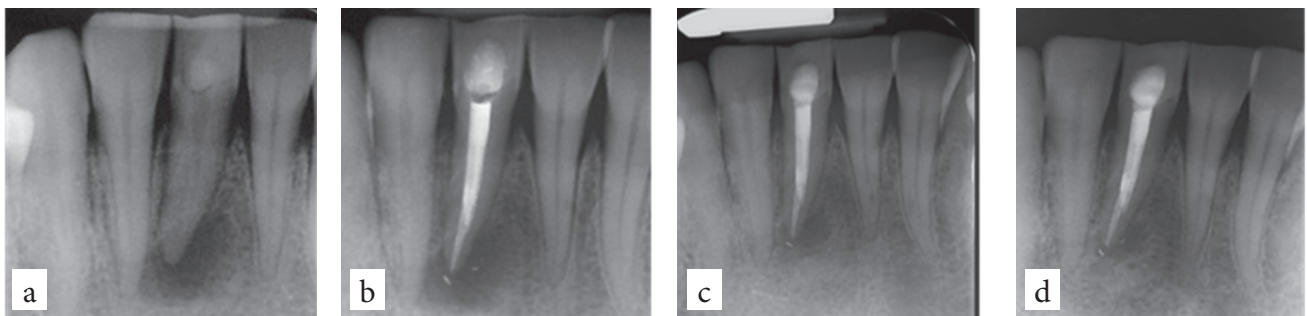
Example of mandibular incisor with well defined radio-transparent periodontitis (PAI 4). After root canal treatment and filling with a very small overfilling, the lesion decreased to PAI 3, the clinical symptoms disappeared, the tooth is functional, but lesion persists at 1 and even 3 years follow-ups as well as overfilling, suggesting an extended period of time for monitoring; a – preoperative radiograph, PAI 4; b – postoperative radiograph; c – follow-up at 1 year, uncertain; d – follow-up at 2 yrs, uncertain.
